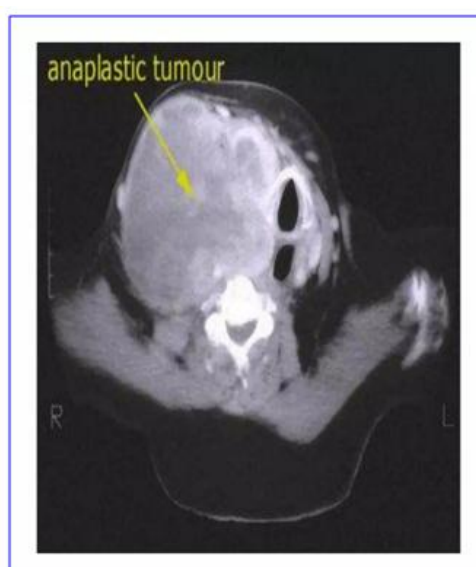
A CT scan showing anaplastic cancer of thyroid (80)
